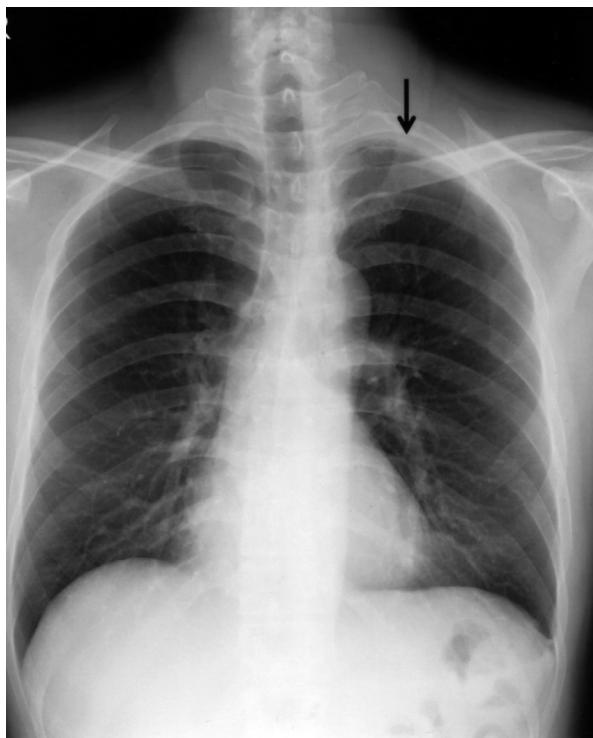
Initial chest radiograph showed increased soft tissue density at the left apical region (arrow).
